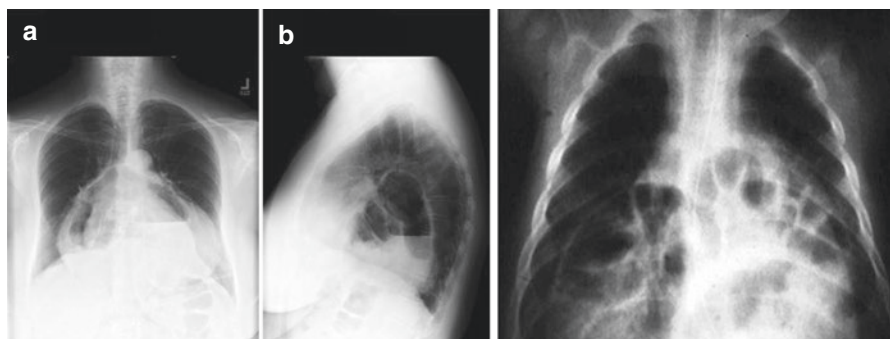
Recurrent hiatal hernia on the PA (a) and lateral plain (b) chest radiographs with air-fluid levels (*on the left*), and with bowel gas in the mediastinum (*on the right*)
